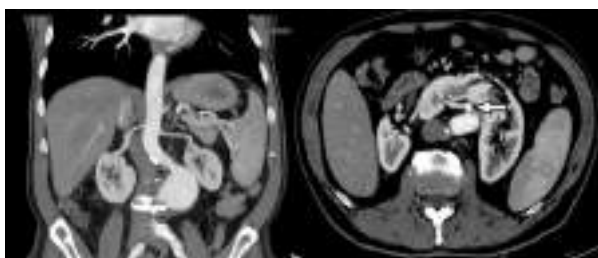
Computed tomography angiography depicting two renal arteries and an abdominal aortic aneurysm. White arrow indicates the isthmus branch.
